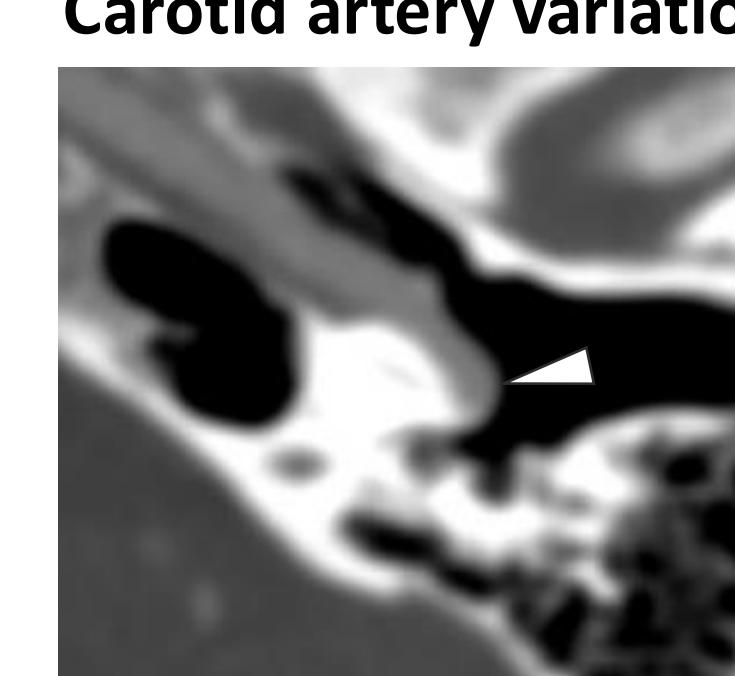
Axial CTA demonstrates an aberrant left internal carotid artery (arrowhead) coursing across the cochlear promontory.
